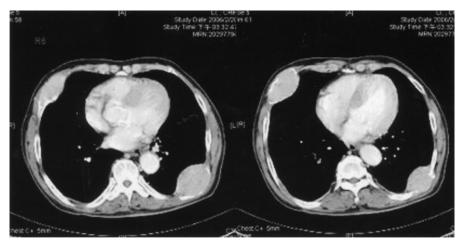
CT demonstrates the soft tissue masses with enhancement, and adjacent rib expansion
